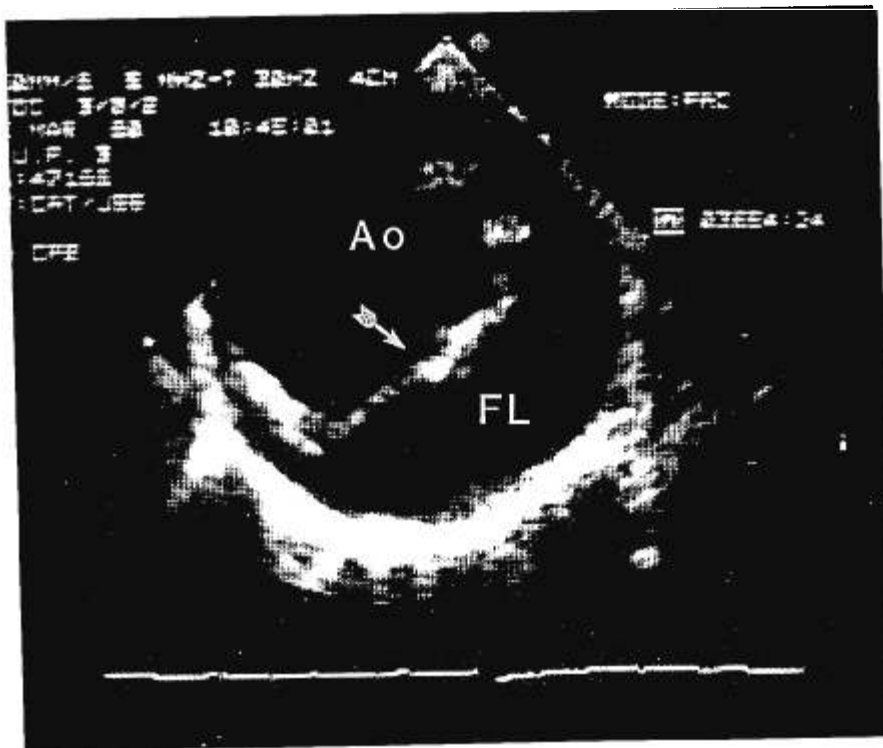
Two-dimensional echocardiogram, basal short-axis view at the level of the aortic root, demonstrating dissection in the ascending aorta. Ao = true lumen; FL = false lumen; LA = left atrium. *Arrow*: intimal flap. Top is posterior.
